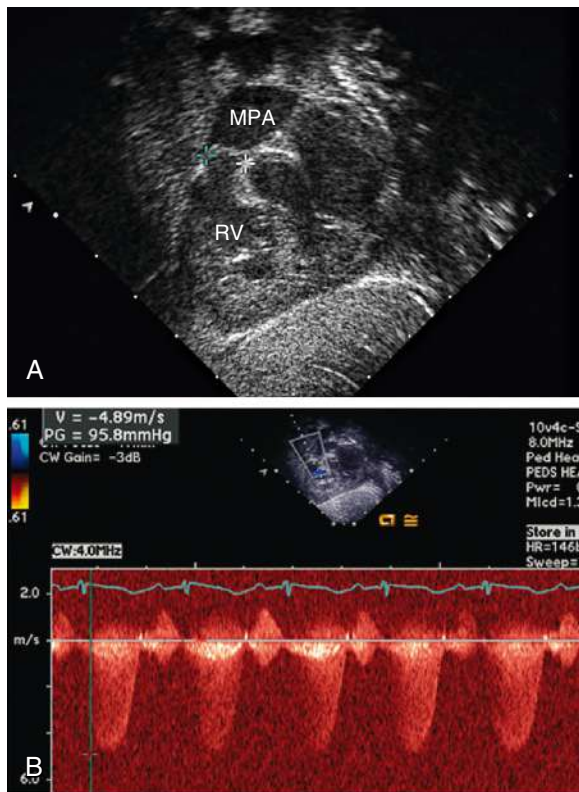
Echocardiogram demonstrating valvar pulmonic stenosis. A, Subcostal view showing thickened pulmonary valve leaflets (between crosshatches). B, Doppler study indicating a 95 mm Hg peak pressure gradient across the stenotic valve. MPA, Main pulmonary artery; RV, right ventricle.
